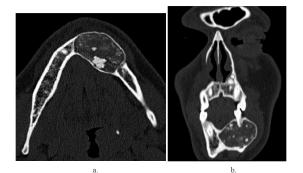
(case 11). Cemento-ossifying fibroma in a 38-year-old male patient. (a) Axial and (b) coronal maxillofacial computed tomography examination showing hypodense heterogeneous lesion with multiple calcifications and smooth contours, causing expansion in the bone structure in the middle-left lateral part of the anterior mandible.
